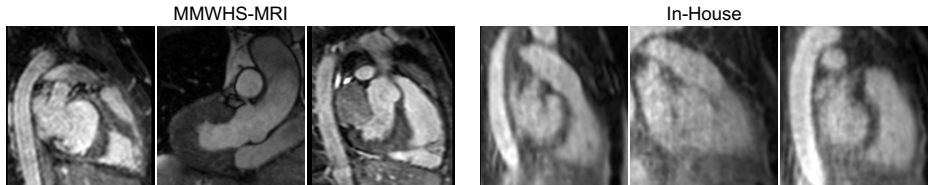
Domain Gap between MMWHS-MRI [32] and In-House Data.
